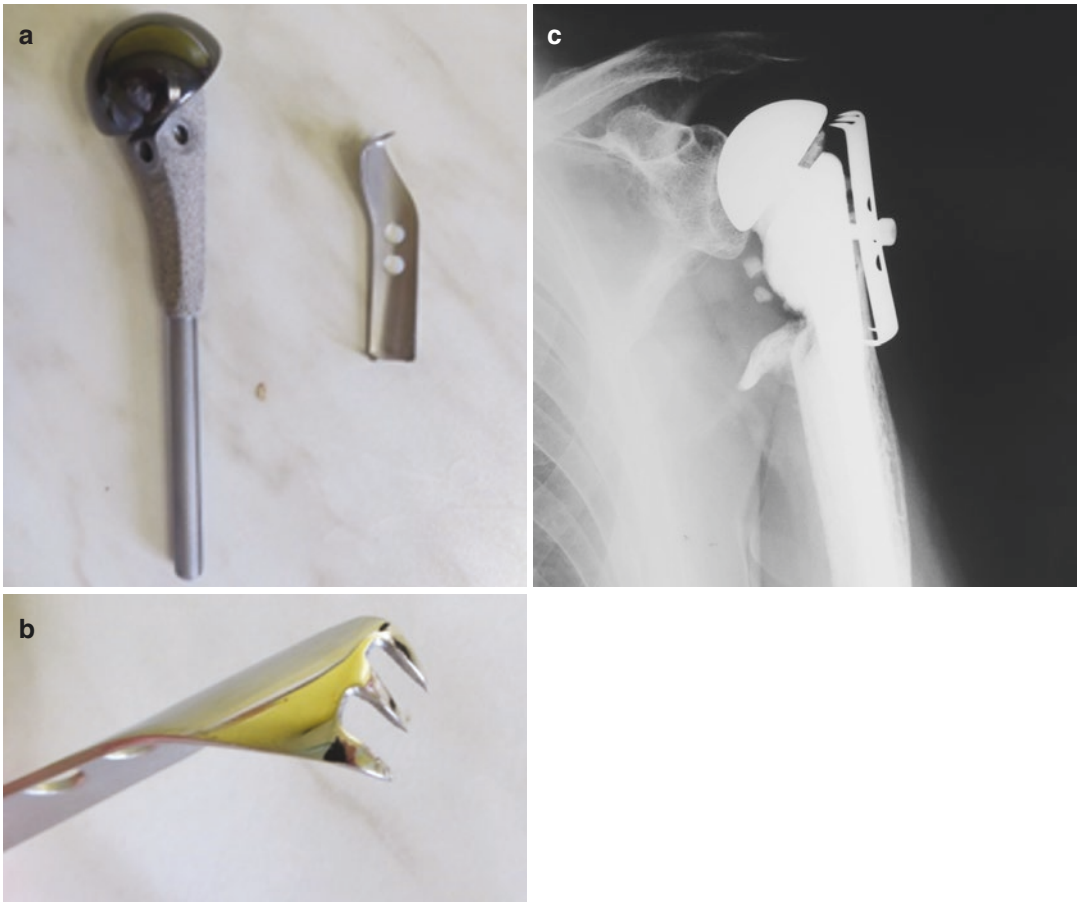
Humeral hemiarthroplasty (a). Dorsal plate for the greater tuberosity fixation (b). Postoperative X-ray (c)
